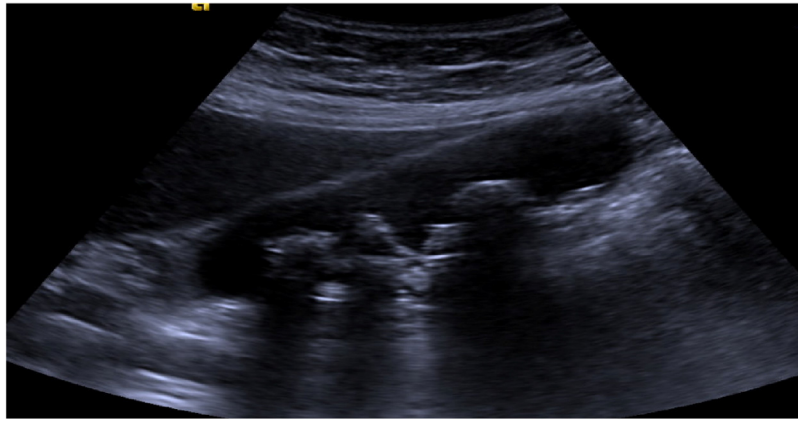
Ultrasound mass showed signs of early cholecystitis.
